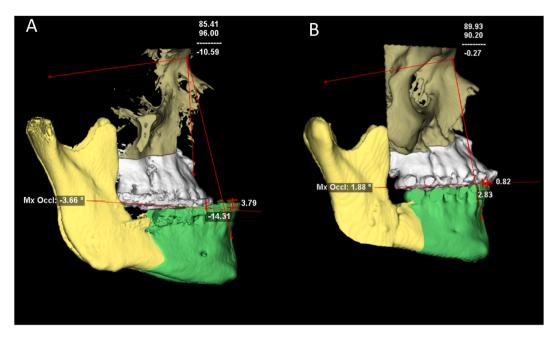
Pre-operative and post-operative CBCT 3D lateral view. A: Pre-operative CBCT 3D reconstruction lateral view, that show cephalometric measures: SNA 85.41 $^{\circ}$, SNB 96.00 $^{\circ}$, ANB-angle -10.59° , overbite -3.79 mm and overjet -14.31 mm. B: Post-operative CBCT 3D reconstruction lateral view, that show cephalometric measures: SNA 89.93 $^{\circ}$, SNB 90.20 $^{\circ}$, ANB-angle -0.27° , overbite -0.82 mm and overjet -2.83 mm.
